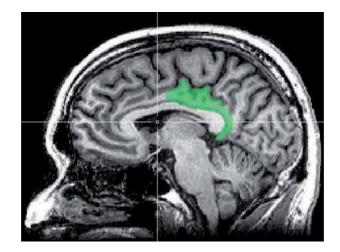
Sagittal MRI slice with highlighting indicating location of the posterior cingulate cortex [15].
